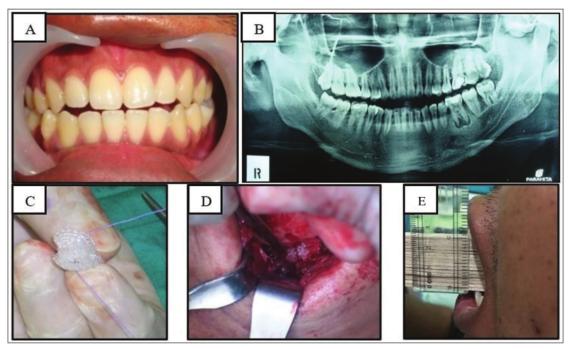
Preoperative mouth opening (A), orthopantomograph view of fibrous ankylosis left TMJ (B), Mersilene mesh sheet (C), interpositional arthroplasty with Mersilene mesh (D), 3 months postoperative mouth opening (E)
